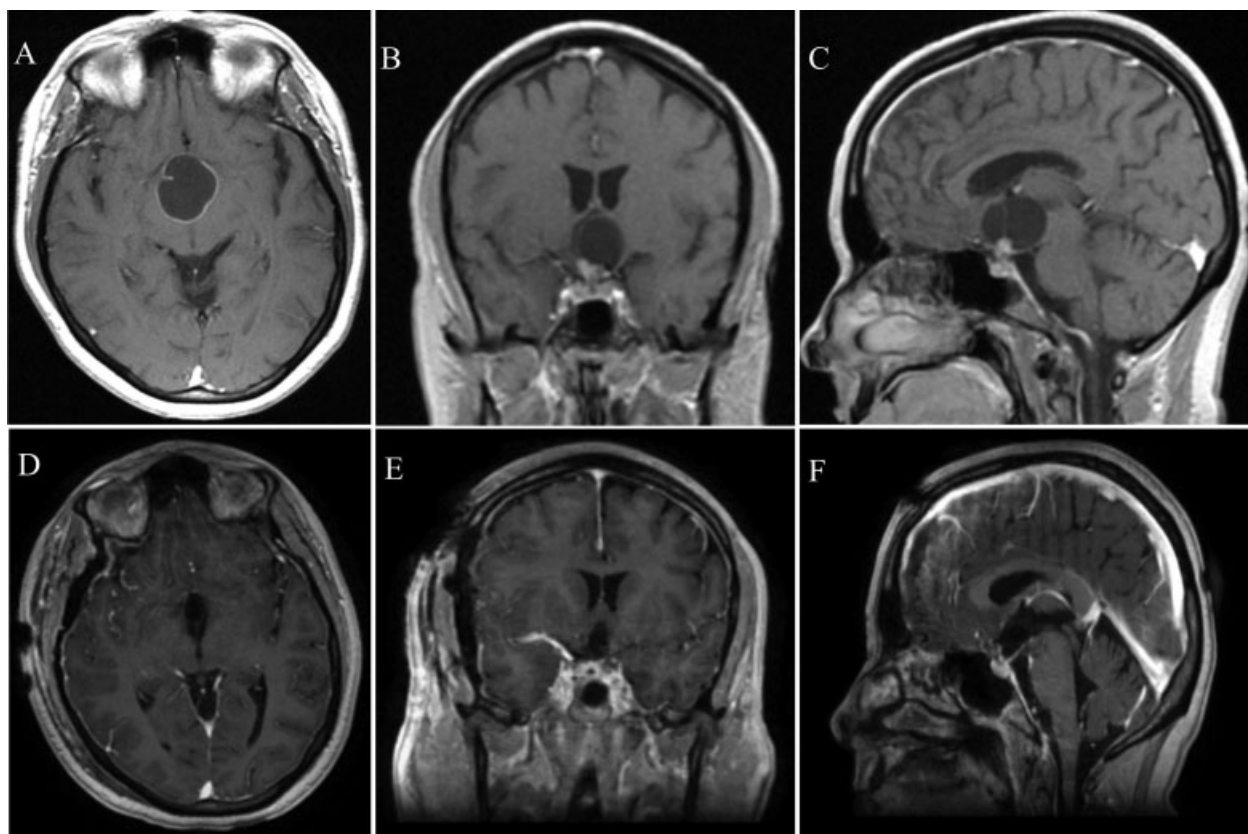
Radiology panel showing pre-op (A–C) and post-op (D–F) gadolinium magnetic resonance images.
